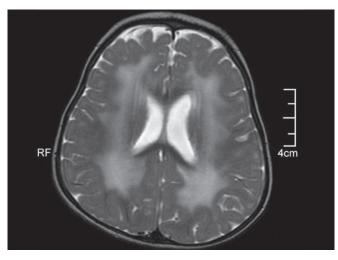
T2 weighted axial sections of magnetic resonance imaging of brain in a patient with merosin deficient congenital muscular dystrophy
